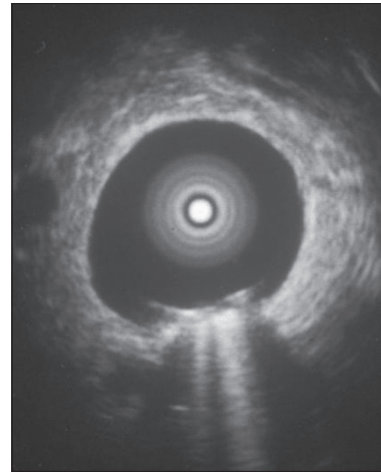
Air bubble in common bile duct seen on intraductal ultrasonography
